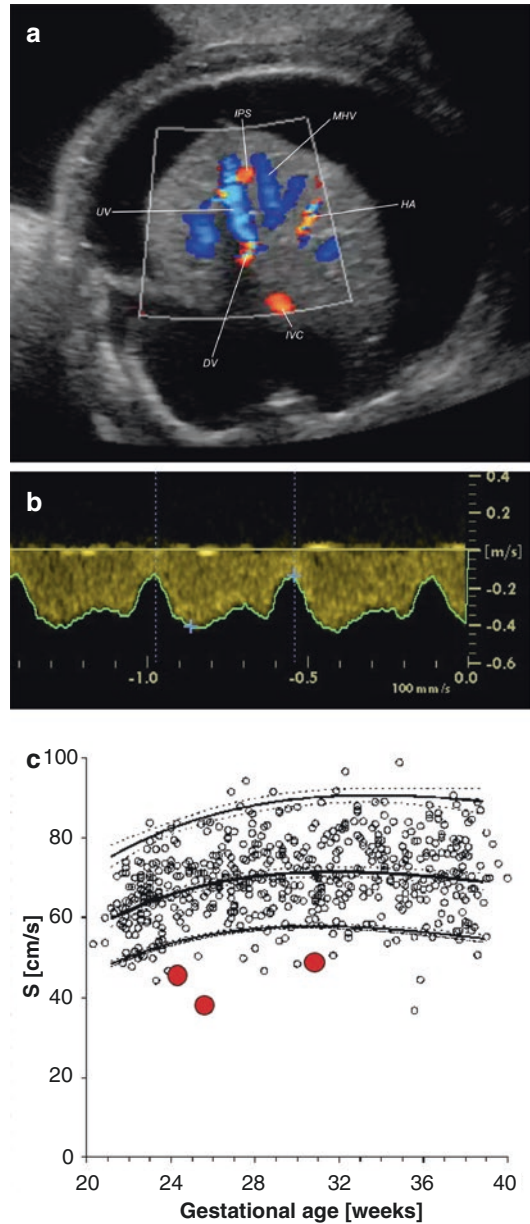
Color Doppler imaging in a case of fetal hydrops in the late second trimester (panel a). Pulsed Doppler recording of the ductus venosus (DV) (panel b) revealed a normal waveform, but the absolute velocity was extremely low (panel c; modified from []) as demonstrated by the repeated observations (red circles) of the systolic peak velocity (S), reflecting the low umbilicocaval pressure gradient. Thus, the liver is hypo-perfused, leading to liver failure with, e.g., reduced albumin production, causing hydrops. The cause is an intrahepatic porto-systemic shunt (IPS) draining blood from the umbilical vein (UV) to the medial hepatic vein (MHV), thus reducing the pressure. An augmented hepatic arterial flow (HA) is a compensatory response that confirms the severity of the condition
